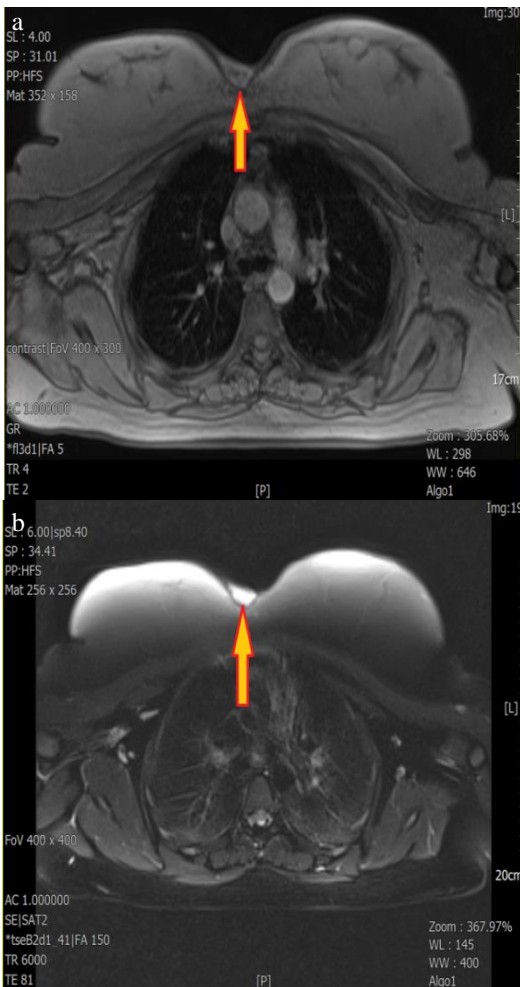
1. MRI scan in axial plane, T1 weighted. 2. MRI scan in axial plane, T2 weighted. MRI of the mass revealed hyperintensity in the T2A, and hypointensity in the T1A sequences
